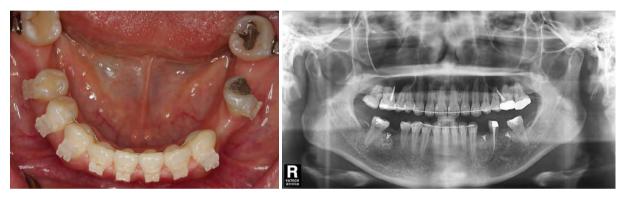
~2. Intra-oral and preoperative radiographic findings. Thin mandibular ridge is seen in extracted site
